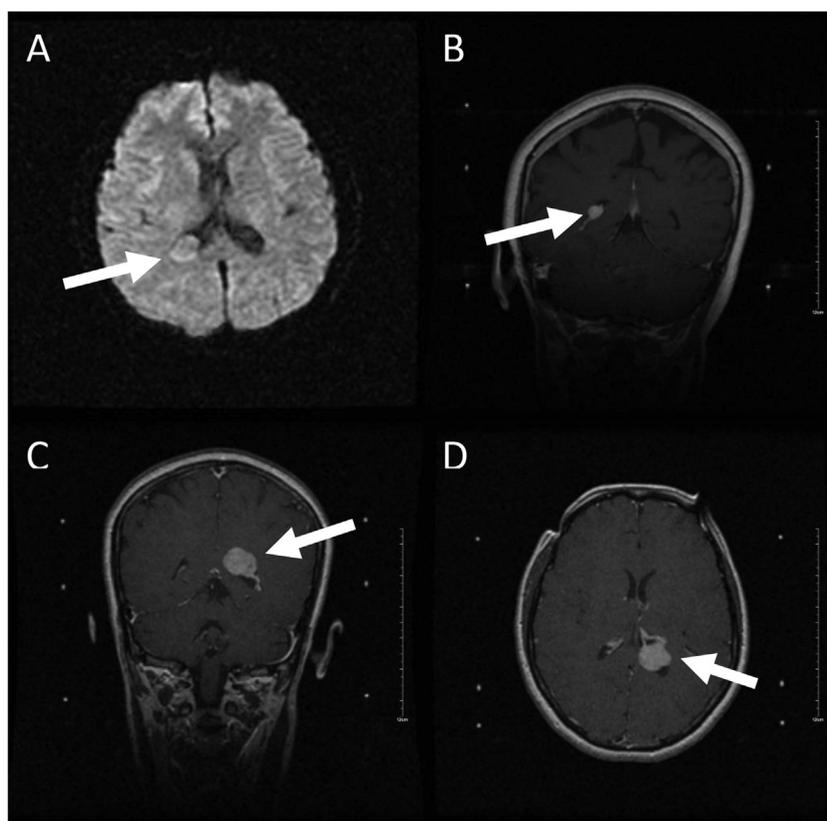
Selected example cases. (A) Diffusion weighted imaging study of a patient with an enhancing mass considered to be an intraventricular meningioma located in the right trigone. (B) T1-weighted, postcontrast coronal magnetic resonance image (MRI) showing a meningioma of the right trigone. The lesion is a suspected intraventricular meningioma and displays a prominent tail. (C) T1-weighted MRI showing a coronal view of an intraventricular meningioma within the left trigone and a characteristic tail. Imaging also displays a uniform contrast-enhancing mass characteristic of meningiomas. (D) T1-weighted MRI showing an axial view of the same intraventricular meningioma seen in panel C.
